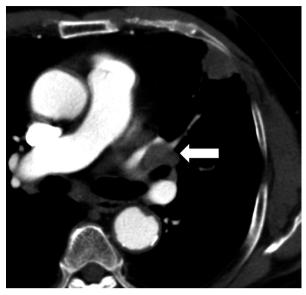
Multidetector computed tomographic angiography reveals left hilar lymphadenopathy with external compression on the left pulmonary artery
